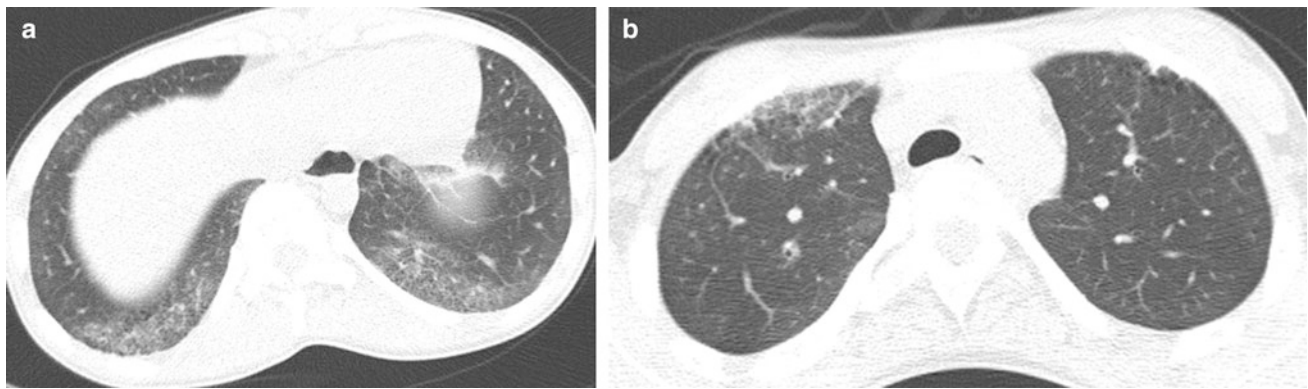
Juvenile systemic sclerosis (JSS). Axial chest CT images (a, b) from a 17-year-old girl with JSS show ground-glass opacities, fine reticular opacities, and tiny cysts at the peripheral posterior lower lobes and peripheral anterior upper lobes, as well as esophageal dilation
